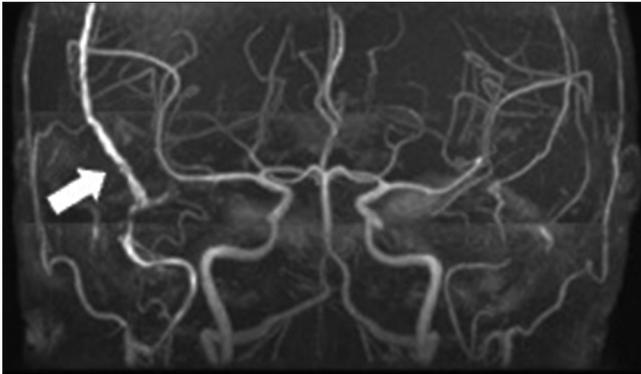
Head magnetic resonance imaging shows the right middle meningeal artery and a vein, indicating shunt disease (white arrow).
